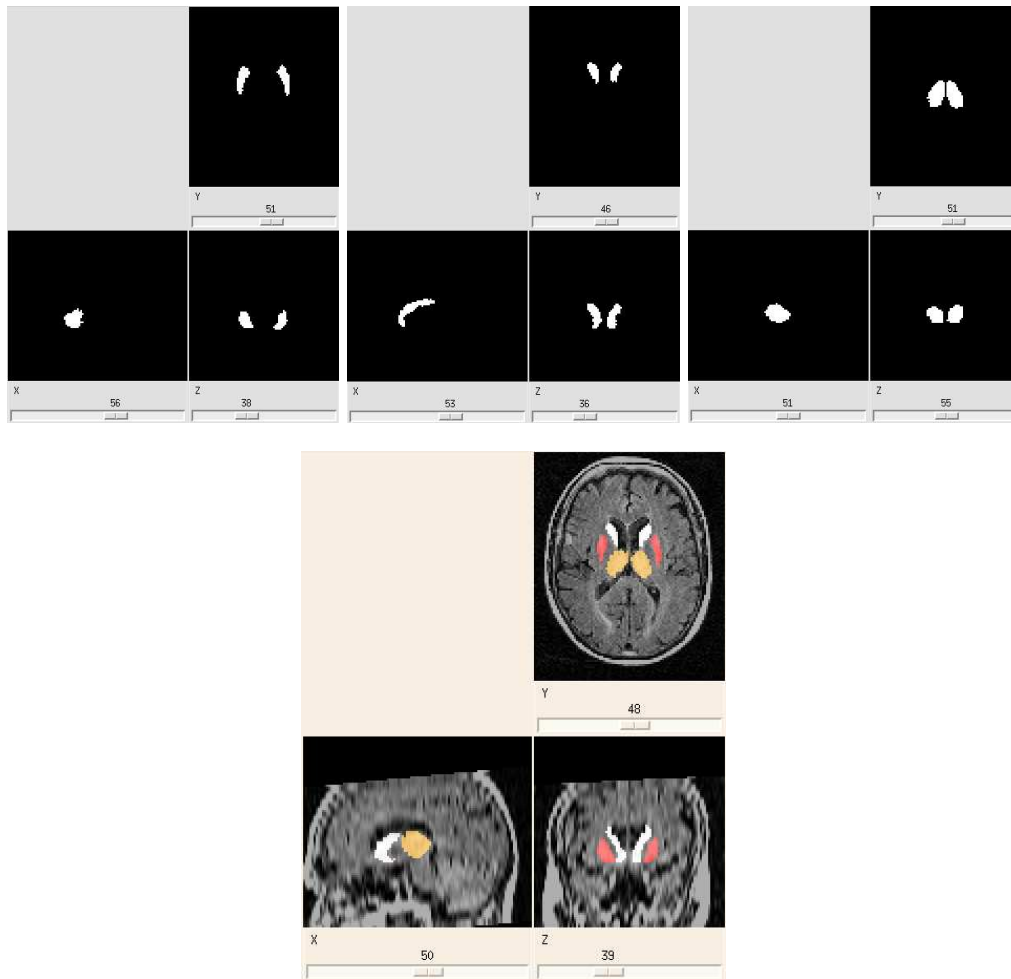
Segmenting the putamen, caudate nuclei and thalami in patient FLAIR images. The first mask on the left is the Zubal putamen mask; the mask in the middle is the Zubal caudate nuclei mask; the mask on the right shows the segmentation of thalami on the Zubal atlas; on the bottom row we have the results of segmentation of putamen, caudate nuclei and thalami on the patient FLAIR image (putamen in red, caudate nuclei in white and thalami in orange) after non rigid registration between the Zubal and patient ventricles.
